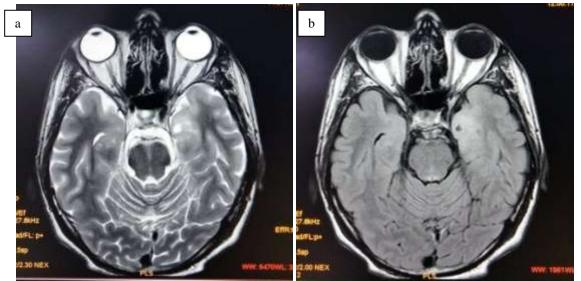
On, axial sections of MRI, there is T2/FLAIR hyperintensity noted in left hippocampus and medial temporal lobe with a T2 hyperintense cystic lesion involving the left hippocampus.
